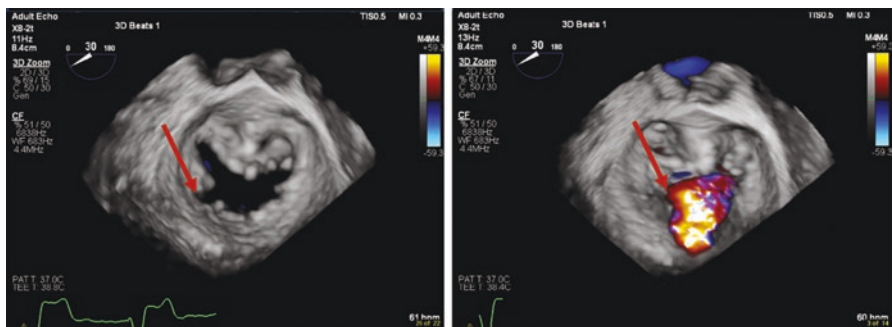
Three-dimensional echocardiography datasets demonstrating cleft in between the lateral and the central scallops of the mural (posterior) leaflet (left-sided image) contributing to the mitral regurgitation mechanism (right-sided image demonstrates enhancement of regurgitation at the level of the cleft)
